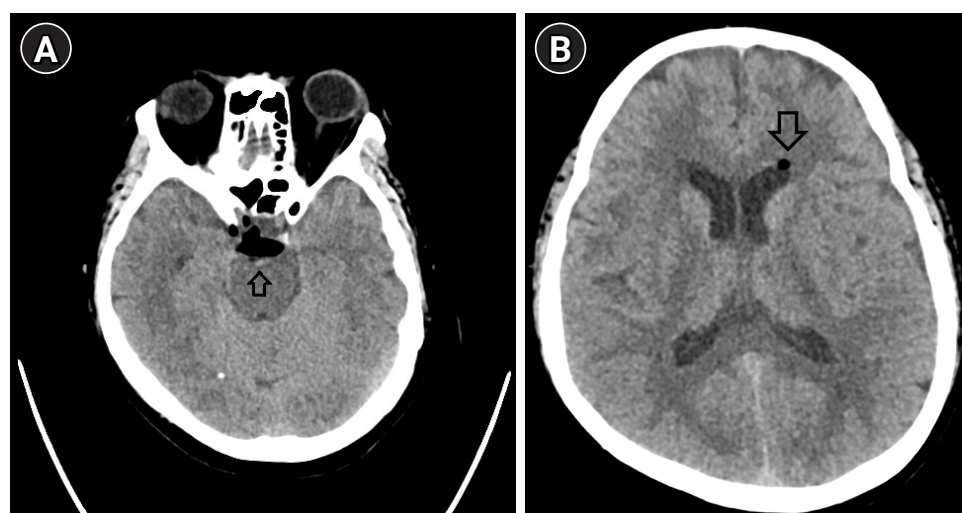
Brain computed tomography (CT) obtained approximately 12 hours after epiduroscopic epidural neuroplasty. (A) Axial CT at the level of the basal cistern showing hypodense air collections in the interpeduncular cistern, consistent with pneumocephalus (arrow). (B) Axial CT at the level of the lateral ventricles showing a small hypodense air bubble in the anterior horn of the left lateral ventricle (arrow).
